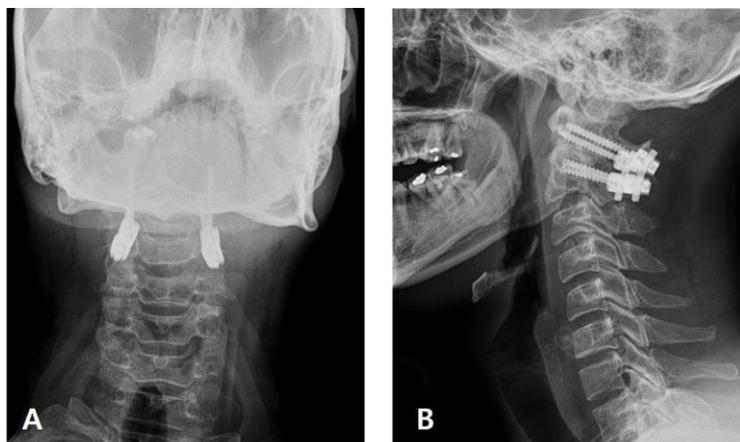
Cervical spine radiography images at 6 weeks postoperatively. The patient underwent posterior fusion on C1 and C2 vertebrae.
